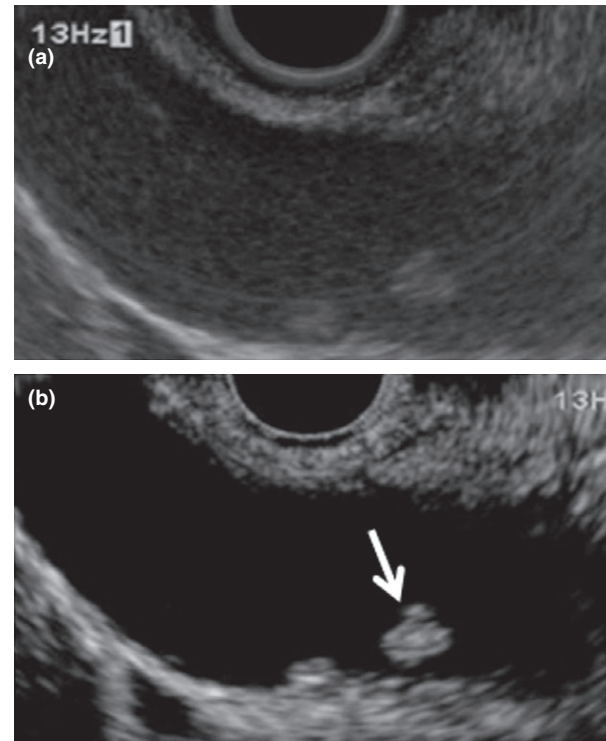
Typical case of a cholesterol polyp. (a) Fundamental B-mode endoscopic ultrasonography (monitor mode). An echogenic mass can be seen in the body of the gallbladder. (b) Contrast-enhanced harmonic endoscopic ultrasonography. The lesion (arrow) demonstrates homogeneous enhancement.
